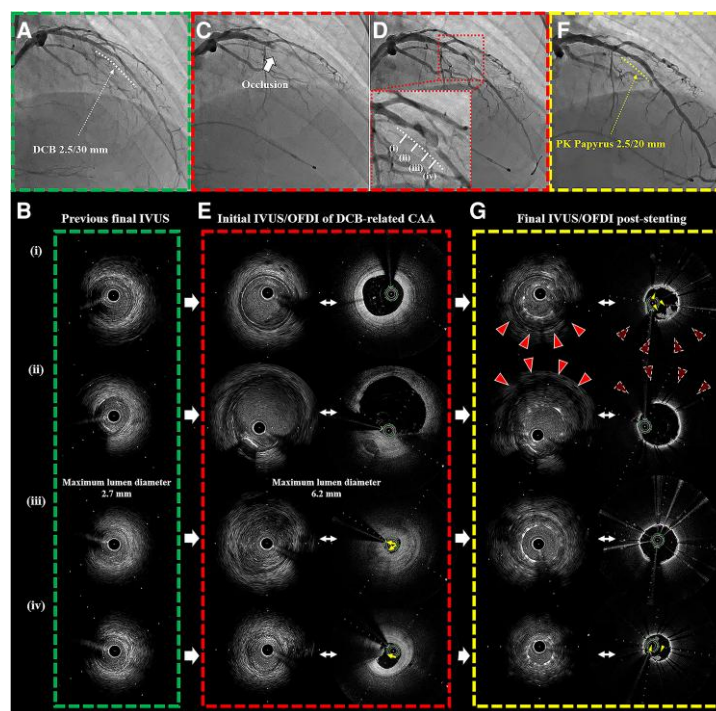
(A) Coronary angiography and (B) intravascular ultrasound after previous percutaneous coronary intervention with a drug-coated balloon angioplasty. Coronary angiography; (C) an acute occlusion in the mid-left anterior descending artery, (D) after thromboaspiration and (F) PK Papyrus-covered stent implantation. (E and G) Comparison of intravascular ultrasound and optimal frequency domain imaging findings; (E) after thromboaspiration and (G) PK Papyrus-covered stent implantation. Intravascular ultrasound visualizes the aneurysm (red arrowheads), but optimal frequency domain imaging cannot visualize it (dotted arrowheads). However, optimal frequency domain imaging indicates thrombus (arrows) before stenting and multiple intra-stent thrombi, which is newly developed after stent implantation (yellow arrowheads).
